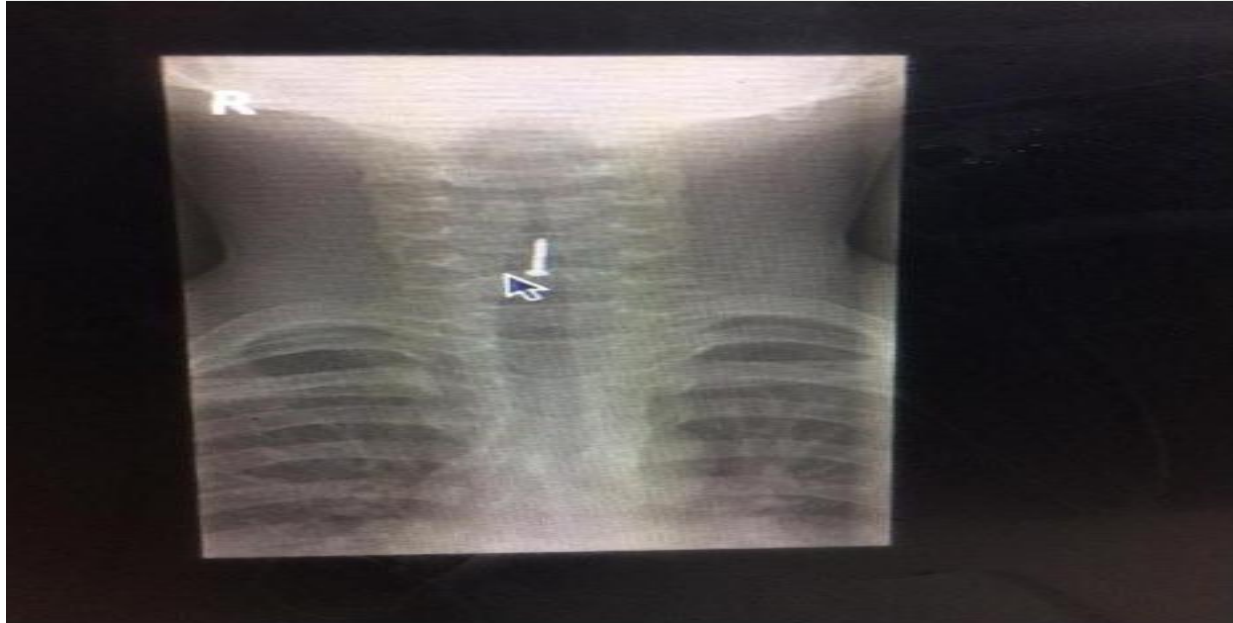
Showing Lateral Soft Tissue Neck Xray With A Radiopaque Foreign Body in the Larynx
